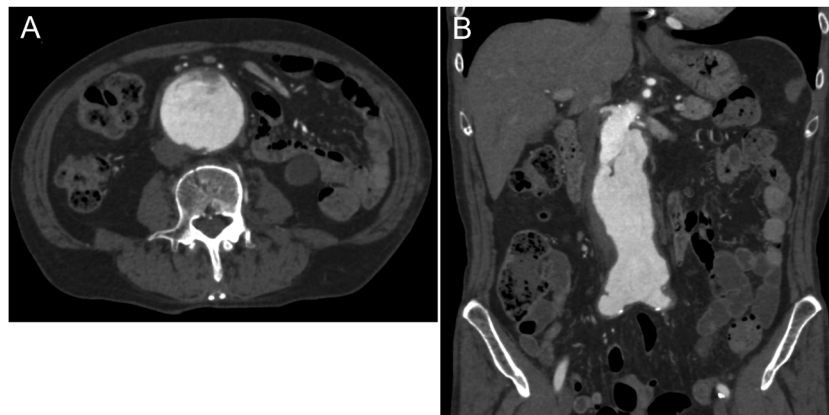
(A) Axial and (B) coronal computed tomography images showing an abdominal aortic aneurysm with irregular mural thrombus.
